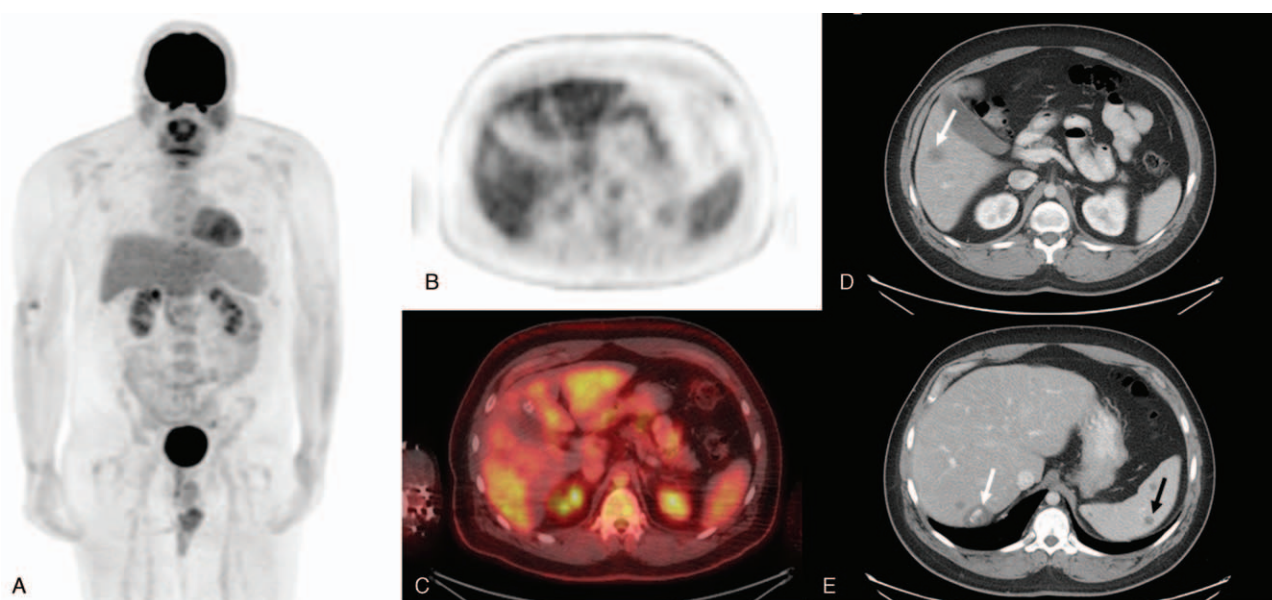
Six years follow-up post chemotherapy treatment with oral cyclophosphamide and Pazopanib. PET/CT scan for restaging shows complete metabolic response to therapy: (A) 3D MIP image, (B) PET scan, and (C) PET/CT scan. No evidence of FDG uptake is seen on the 3D MIP image in coronal view, PET scan, and PET/CT scan. (D) Portal phase post-contrast CT scan shows the treated lesion in hepatic segment 5/6 (white arrow). (E) Portal phase post-contrast CT scan shows that some of treated lesions were unchanged in size but had partial calcifications, e.g., lesion in hepatic segment 7 (white arrow) and splenic lesion (black arrow). MIP=maximum intensity projection, PET/CT=positron emission tomography/contrast-enhanced computed tomography.
